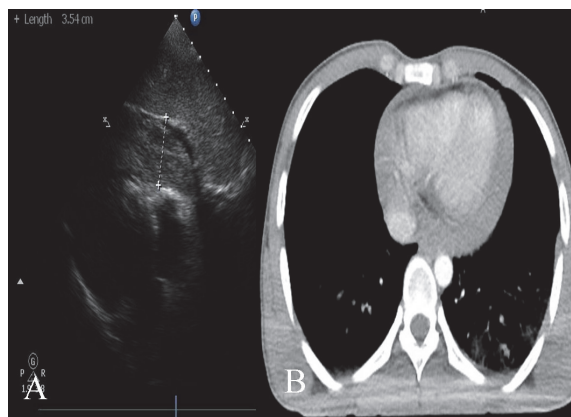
Echocardiographic image of pericardial effusion and compression of right ventricle. 1b. Contrast-enhanced computerized tomography image of pericardial effusion and flattened heart sign
